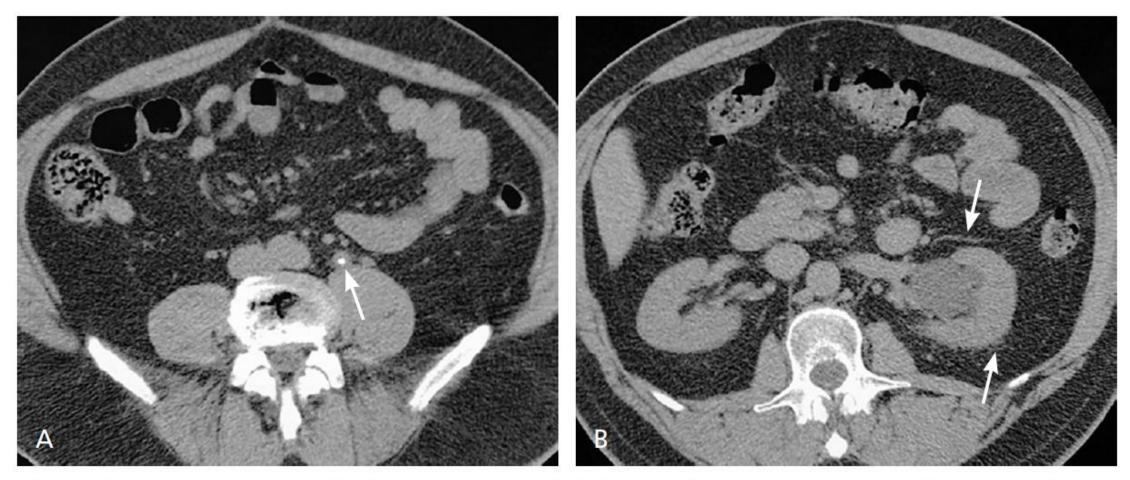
Unenhanced multiphasic computed tomography urography in a 46-year-old man with hematuria and colicky pain in the left flank demonstrates (A) left midureteral calculus with "tissue-rim sign" (arrow) and (B) proximal hydronephrosis with minimal perinephric fat stranding (arrows).
